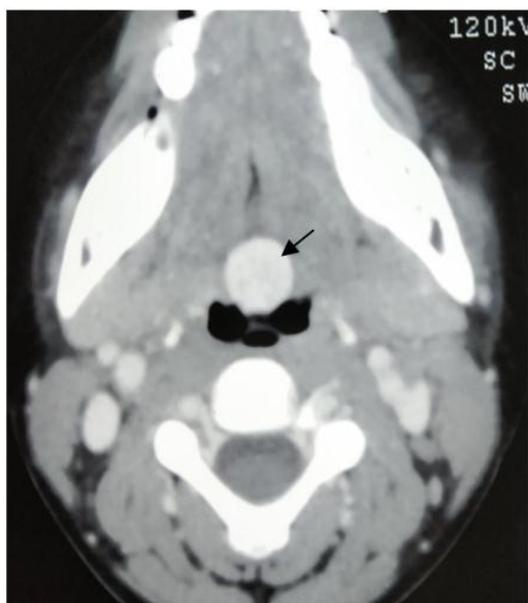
Head and neck contrast-enhanced axial computed tomographic (CECT) scan showing a tissue density in the midline at the base of the tongue (arrow).
